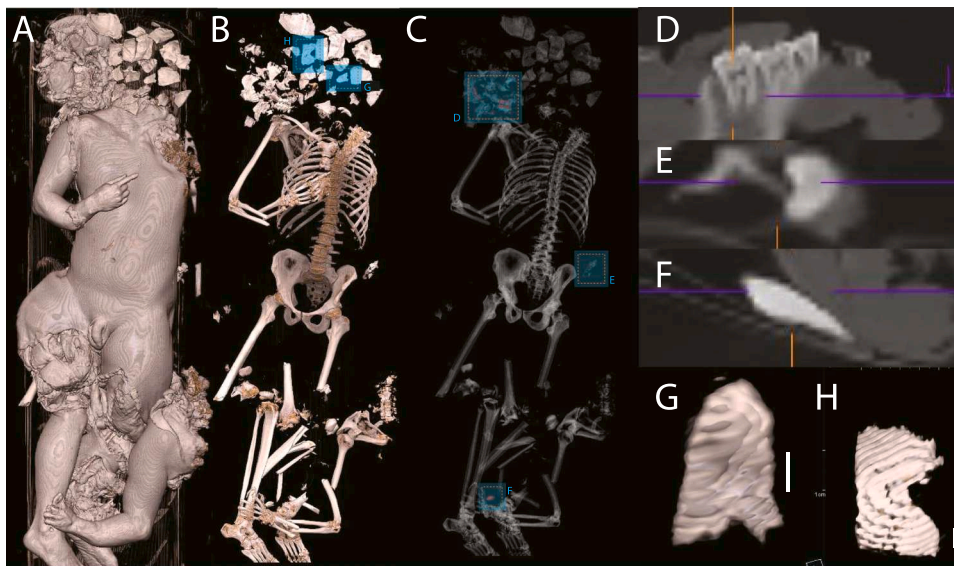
PMCT reconstructions showing VRT at skin density (A), at bone density (B), and (C) at high CT density (red: $>\sim 2100$ Hounsfield units). Location of images D–H relative to body marked in B and C. – No metal fragments were identified; details of dense materials (D, E, F) show these are teeth. – Two bone fragments at whole body PMCT resolution showed what appeared to be fracture margins consistent with the assumption of a pistol shot inflicted perforation or defect (fragment 1: G, fragment 2: H; details see Fig. 2 and 3). Bar (G, H) 1 cm.
